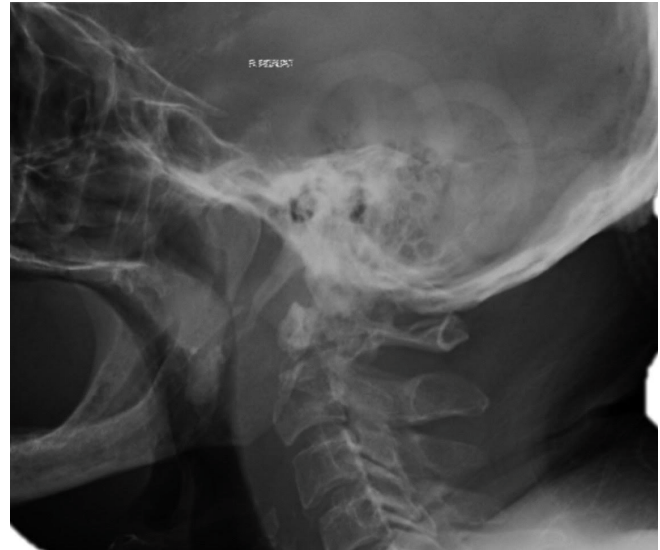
Cervical spine radiographs showing a destructive lesion with gross occipitocervical instability.
